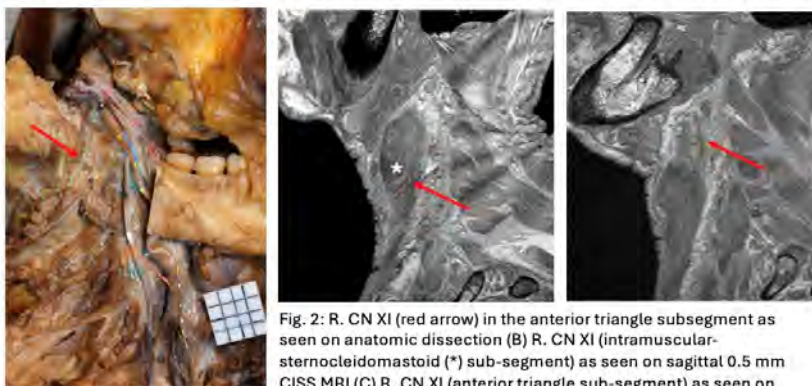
R. CN XI (red arrow) in the anterior triangle subsegment as seen on anatomic dissection (B) R. CN XI (intramuscular-sternocleidomastoid (\*) sub-segment) as seen on sagittal 0.5 mm CISS MRI (C) R. CN XI (anterior triangle sub-segment) as seen on sagittal 0.5 mm CISS MRI
